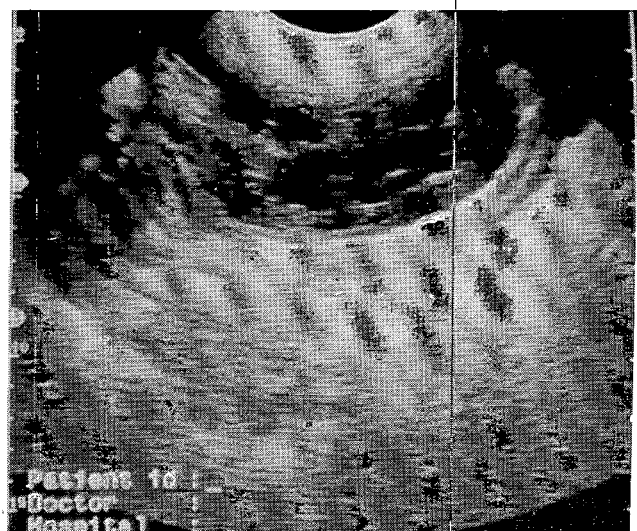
A dilated anechoic pelvis and ureters in ultrasonography.
